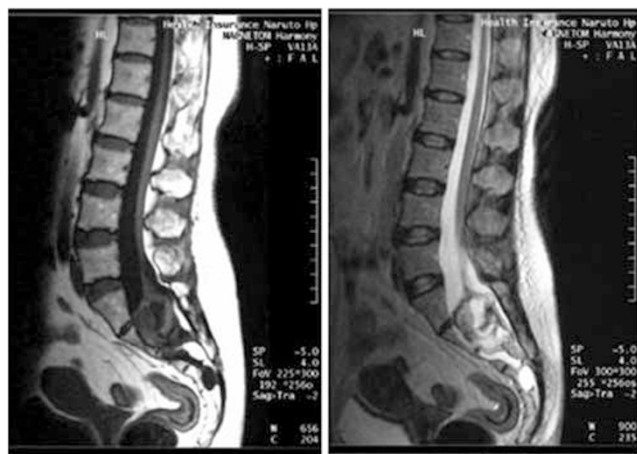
MR image of the lumbosacral regions demonstrated a heterogeneous intradural lesion extending from S1 to S3 level. The mass of low-signal intensity on the T1 weighted and high-signal intensity on the T2 weighted. The conus terminated intradural mass at L5
